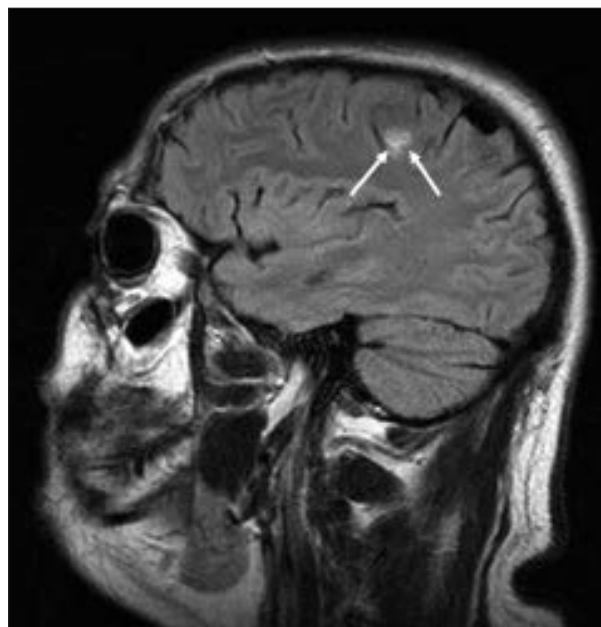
MRI scan: sagittal, T2-weighted image of Case 10 with multiple sclerosis with a juxtacortical lesion (white arrows).
